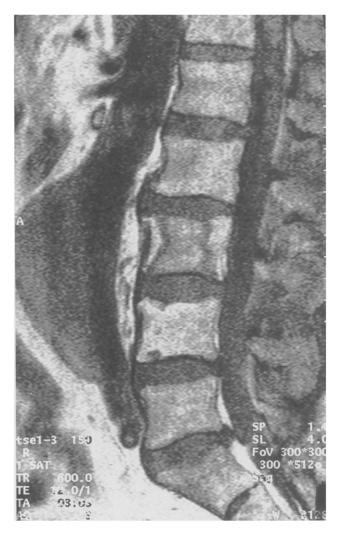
Sagittal T1-W MRI of the lumbar spine with vertebral body infarction of L3.
